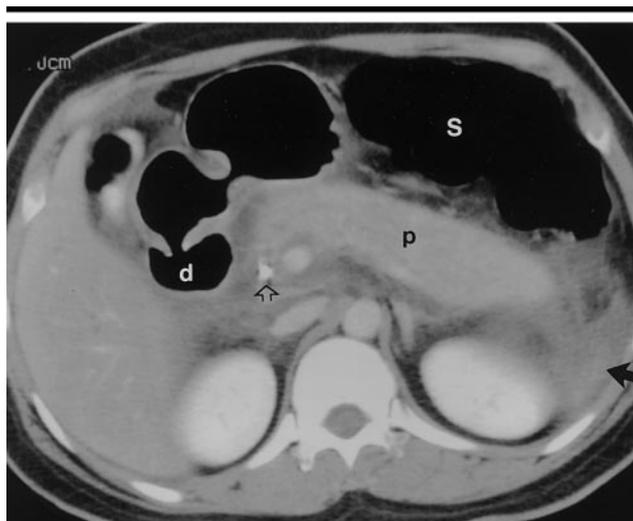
Pancreatitis induced by endoscopic retrograde cholangiopancreatography (ERCP) in a 37-year-old woman. Transverse CT scan obtained with intravenous and oral contrast material shows an enlarged and homogeneously enhancing pancreatic gland (*p*). Residual contrast material from recent ERCP is seen in the common duct (open arrow). Extravasated fluid (solid arrow) is present around the gland. The patient had an uneventful recovery. *d* = duodenal bulb, *S* = stomach.
